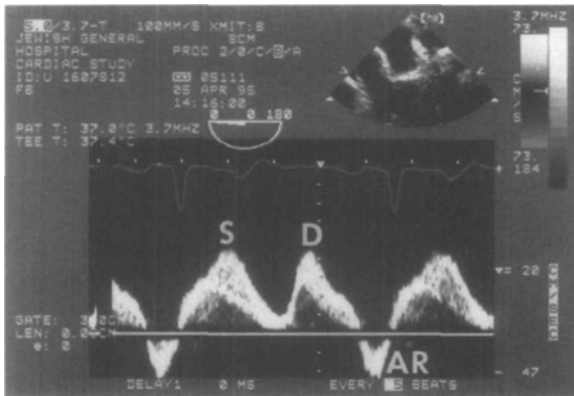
Pulsed wave Doppler tracing of left upper pulmonary venous flow.
